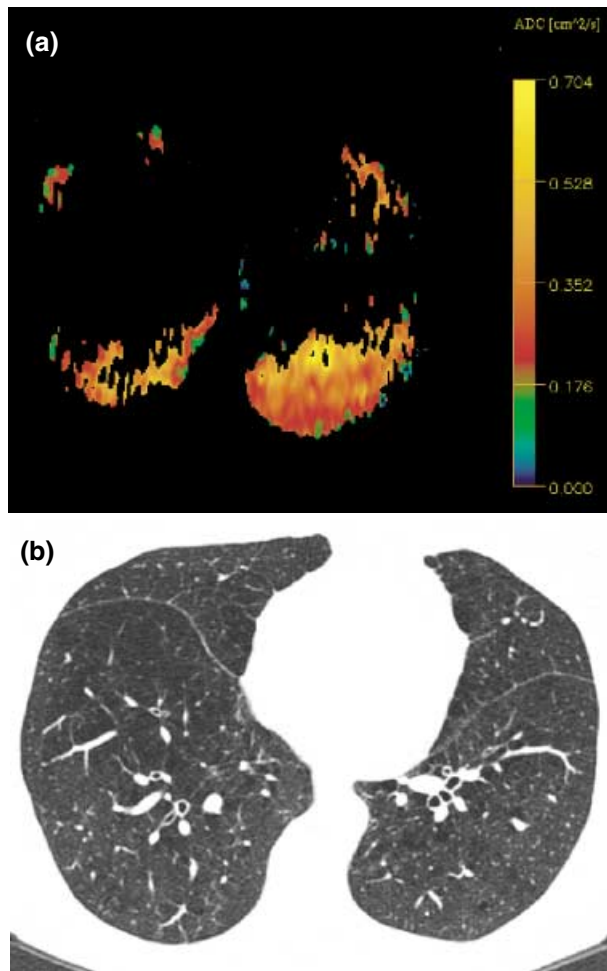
A 63-year-old female patient with emphysema. (a) The colour-coded map of the apparent diffusion coefficient (ADC) shows increased values with a mean of $0.35 \text{ cm}^2 \text{ s}^{-1}$. ADC values cannot be determined within large ventilation defects. (b) Corresponding CT also shows widespread emphysema.
